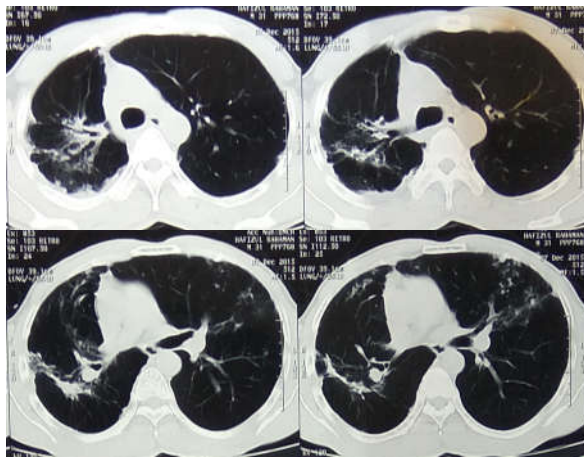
HRCT of same patient (figure 17) shows characteristic right upper and middle lobar interstitial fibrosis with traction bronchiectasis & ipsilateral mediastinal shift.
